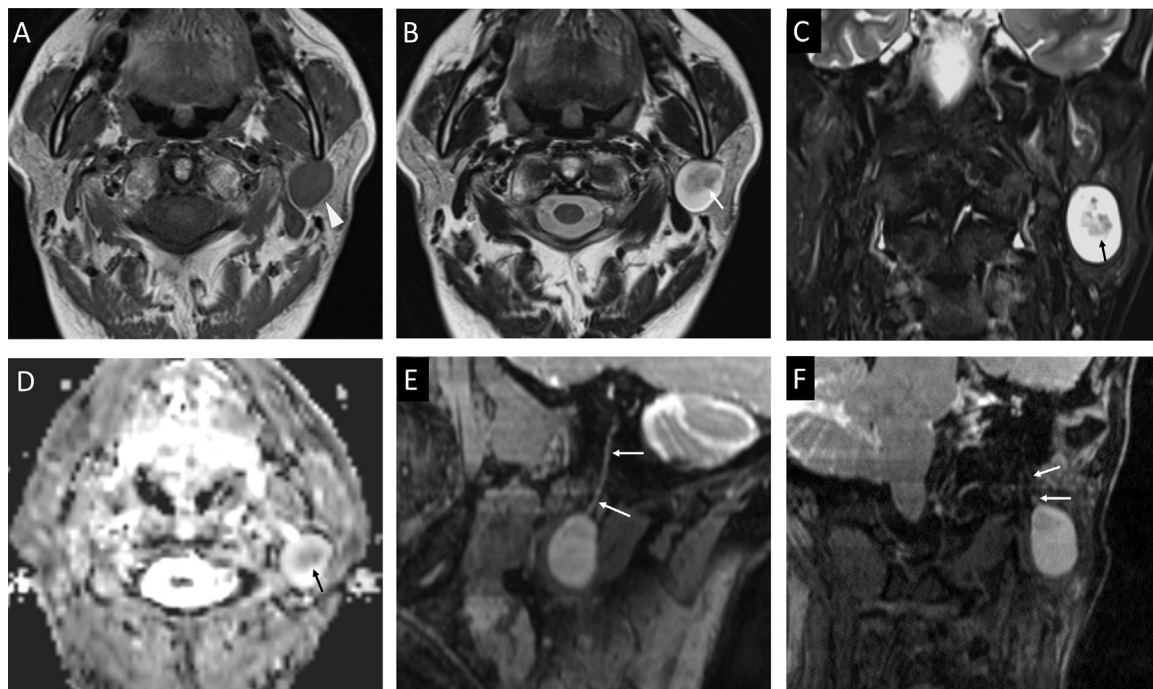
MR imaging findings. The known lesion (arrowhead) demonstrates low signal intensity on the T1-weighted axial image (A). T2-weighted axial image (B) and short tau inversion recovery (STIR) coronal image (C) show high signal intensity at the periphery and low signal intensity (arrows) in the center of the lesion. The apparent diffusion coefficient (ADC) map (D) reveals an ADC value of $1.4 \times 10^{-3} \text{ mm}^2/\text{s}$ in the central portion of the lesion (arrow), which corresponds to low signal intensity region on T2-weighted image or STIR. The 3D double-echo steady-state with water excitation oblique-sagittal image (E) and oblique-coronal image (F) demonstrates continuity (arrows) between the mass lesion and the facial nerve.
